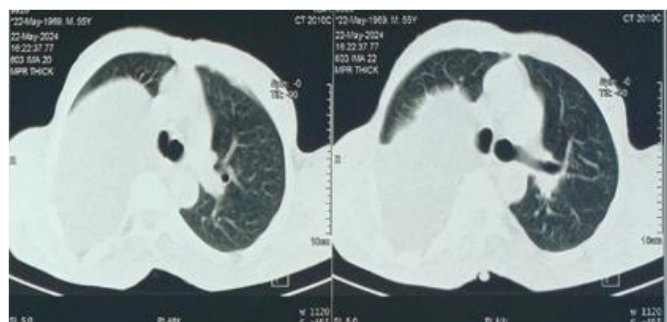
CT scan showing large thin-walled cystic density lesion in right upper hemithorax at superior mediastinum. No abnormal enhancement was seen after contrast injection
